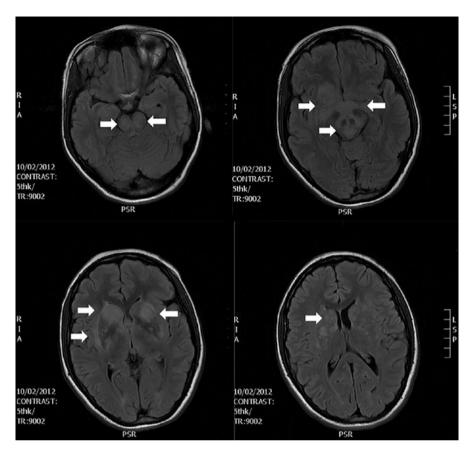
Axial T2 fluid-attenuated inversion recovery (FLAIR)-weighted images of brain MRI in the acute encephalitic phase. Hyperintense T2 lesions are present in both caudate nucleus and lenticular nucleus, both hypothalamus and internal temporal region, as well as both cerebral peduncles (see *white arrows*). Gadolinium enhancement was seen on striatum, anterior commissure, and right temporal intern region
